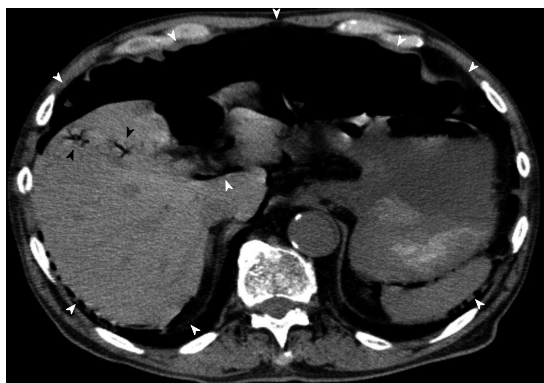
Computed tomography scans also showing widespread, massive pneumoperitoneum (white arrowheads). Moreover, portal venous gas was identified in close proximity to the liver, which was suggestive of portal venous gas in the peripheral portal system, and ascites was not observed (black arrowheads).
